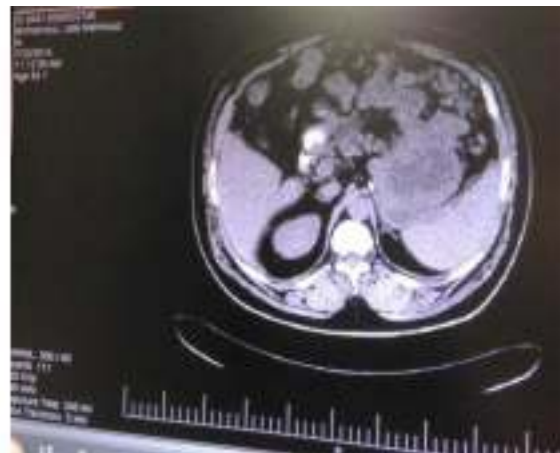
CT of malignant GIST (before treatment)
